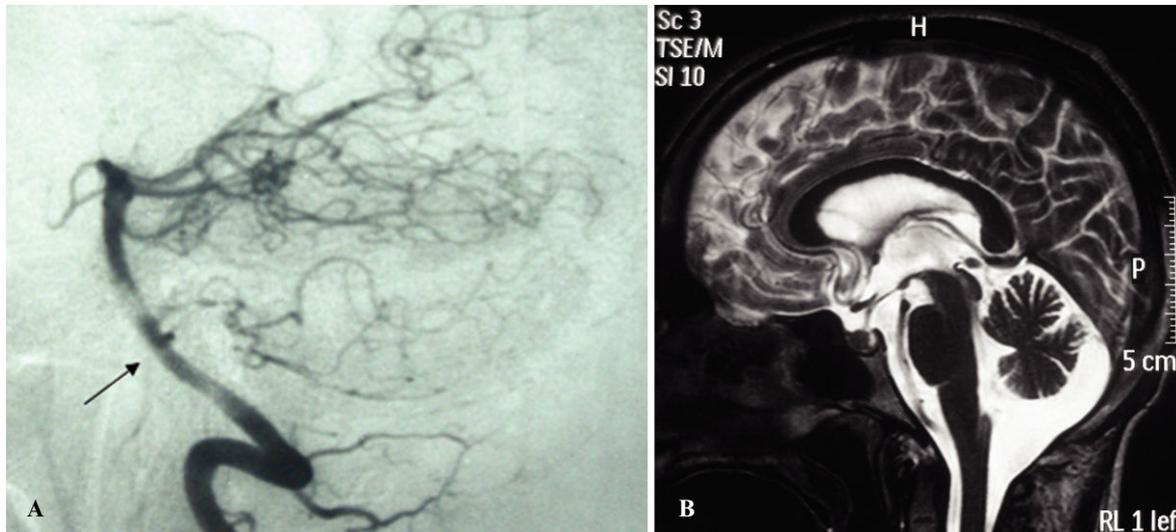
A) Cerebral angiography at admission revealed a small saccular aneurysm of the basilar artery near the emergence of the anterior inferior cerebellar artery (AICA). B) T2-weighted Magnetic Resonance Imaging (MRI) at the one-year follow-up revealed cerebellar atrophy.
